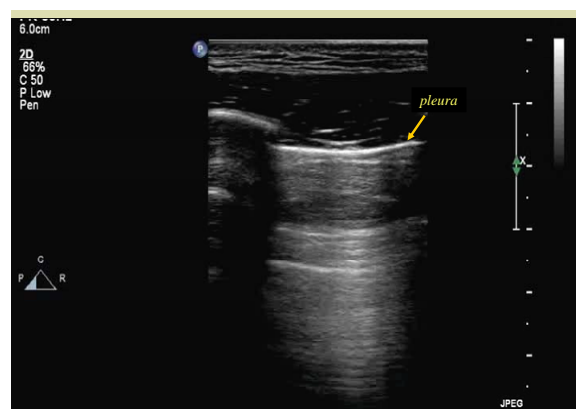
Lung ultrasound – the pleura is visualised as a hyperechoic horizontal line, moving synchronously with the lung during respiration.
